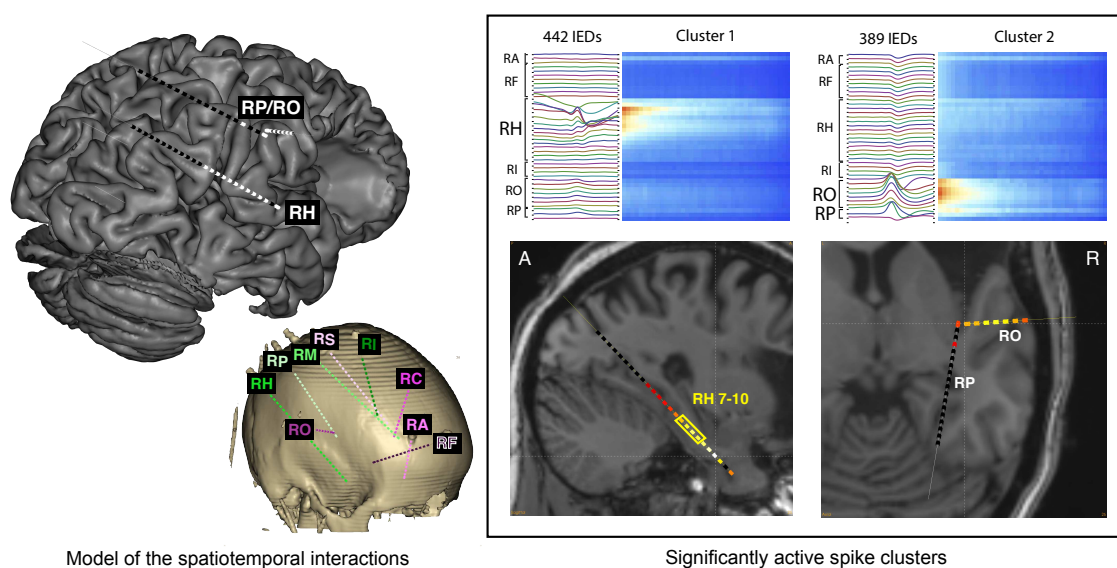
The results of the SEEG analysis for patient 1, indicating the spatiotemporal pattern of the two spike clusters (upper right) and visualizing the significant activation at the electrodes RH, RO and RP (bottom right). The yellow box indicates the overlap of the activity underlying the IEDs and the SOZ. The model of the spatiotemporal interactions (top left) displays the electrodes with significantly involved activity underlying the IEDs indicated by the white dots. The nine electrodes implanted for this patient are displayed together with the 3D-CT scan of the patient's head (bottom left).
